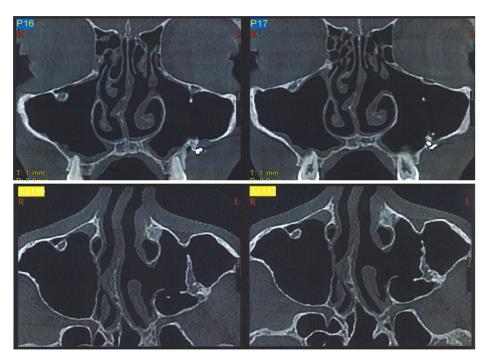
Coronal and axial computed tomography images obtained at 27 months after surgery. The patient was treated with functional endoscopic sinus surgery (FESS) combined with an intraoral approach. There are no changes from the 6-month findings, with no signs of recurrence.
